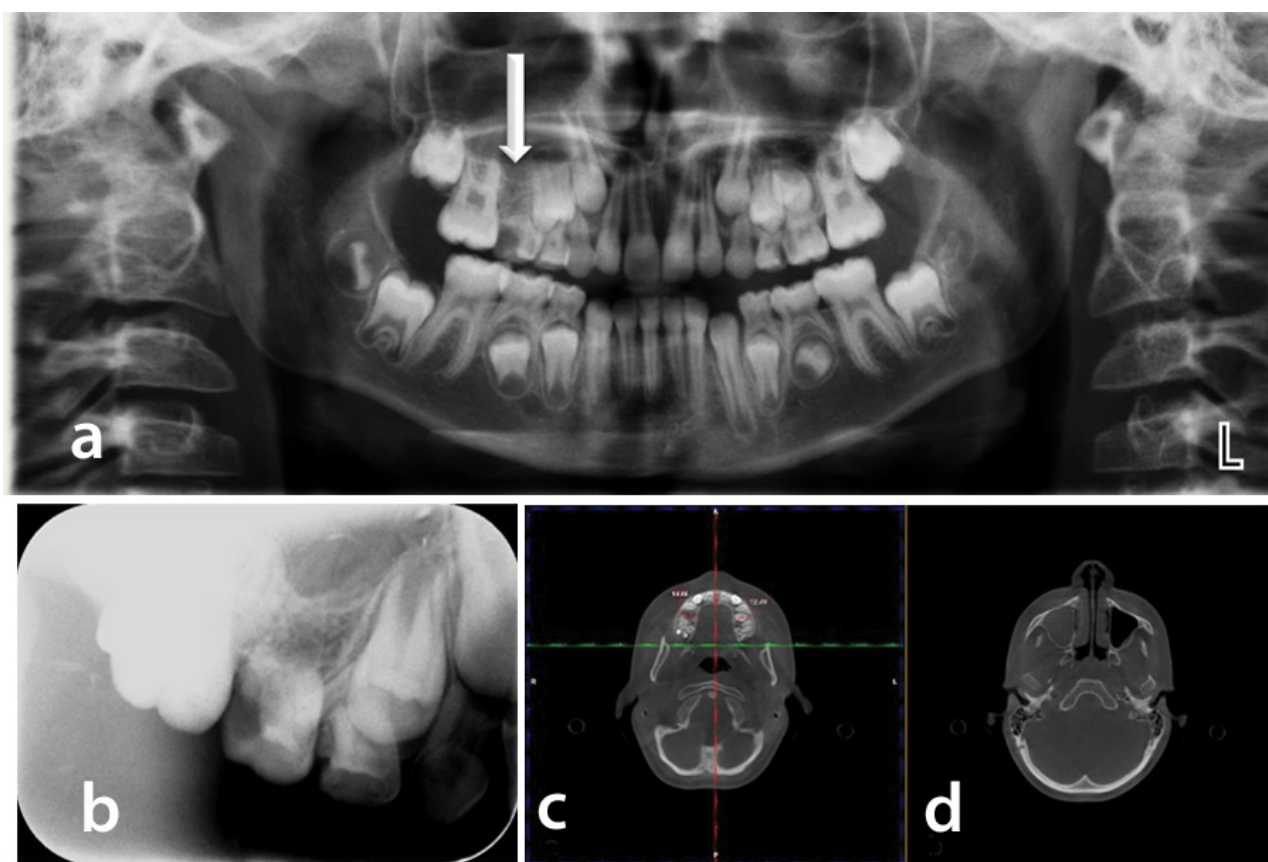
(a,b) Panoramic and periapical radiographic images taken at the time of examination showed that the affected maxillary posterior bone showed altered, irregular and vertically oriented trabeculae. Periapical radiographic image showed hypodontia of the permanent maxillary right second premolar along with resorbed and carious deciduous molars; (c) Axial CBCT scans indicated slightly enlarged right maxillary posterior alveolar ridge with irregular bone when compared to left side alveolar ridge; (d) Fluid retention in maxillary sinus along with nasal airway obstruction was easily detected.
